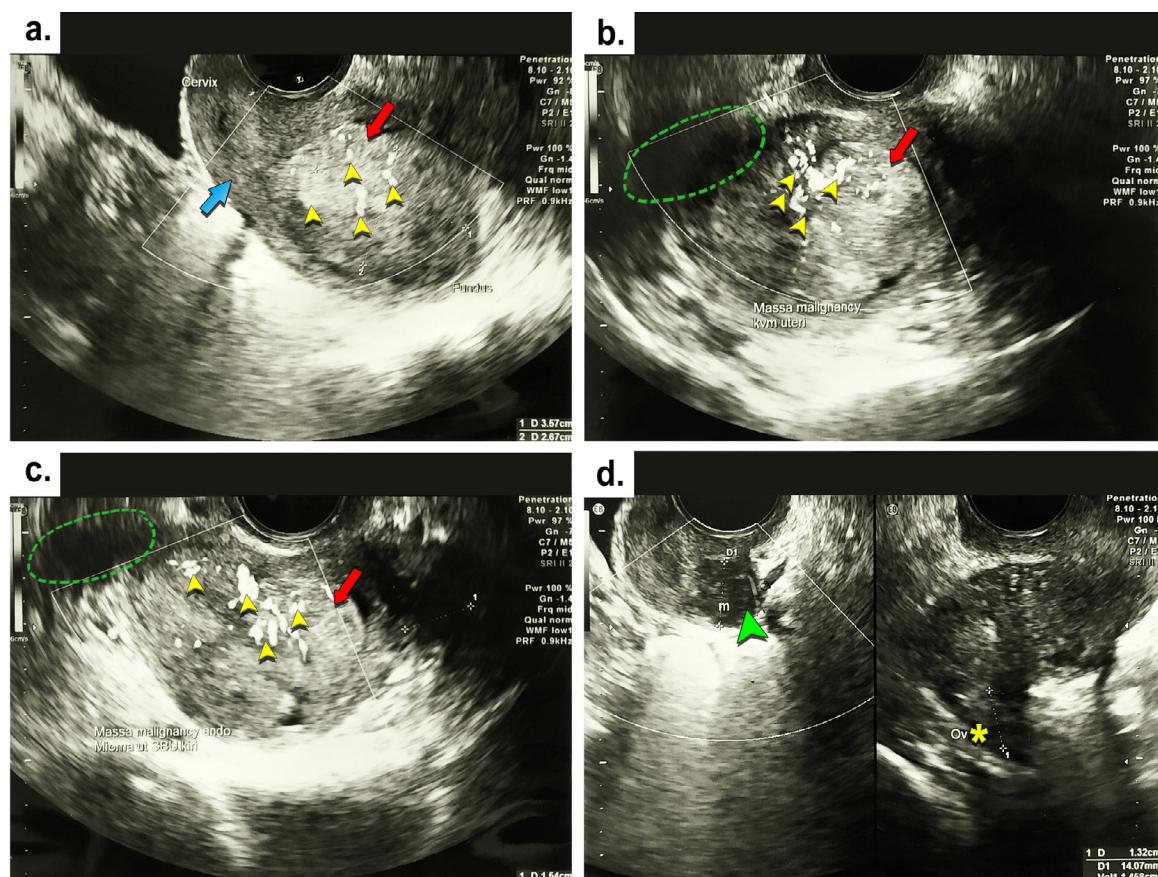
Transvaginal ultrasound (TVUS) findings. (A) A blue arrow shows the endometrium with the cervix at its tip. The image was visualized as a retroflexed uterus with a standard shape but slightly enlarged size. The endocervix and the cervical portion were within normal conditions. (A–C) The red arrow identifies an echogenic mass in the uterine cavity with a dimension of 36 × 27 mm and irregular edges originating from a suspected malignancy of the endometrial wall that had not penetrated the serosa and myometrium. The multiple yellow arrowheads indicates blood flow. (B, C) The shape indicated with the green dotted line depicts the possible location of the myoma. (D) A green arrowhead presents a well-defined hypoechoic mass in the lower-left uterine segment, 30 mm in diameter, which is suggested to be from an intramural uterine myoma. A yellow asterisk indicates a normal right ovary with no suspicious adnexal mass. (Color version of figure is available online.)
